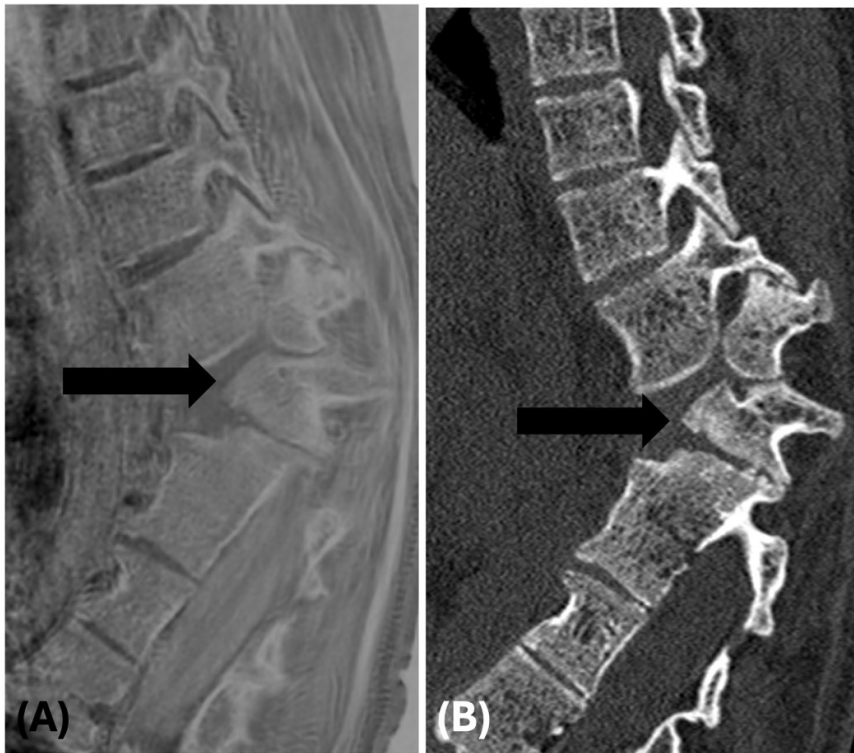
(A) Sagittal CS-FRACTURE MR and (B) CT of the thoracolumbar junction of a 12-year-old show complex fusion segmentation anomaly in form of block and hemivertebrae resulting in a sharp kyphotic deformity (black arrows).
